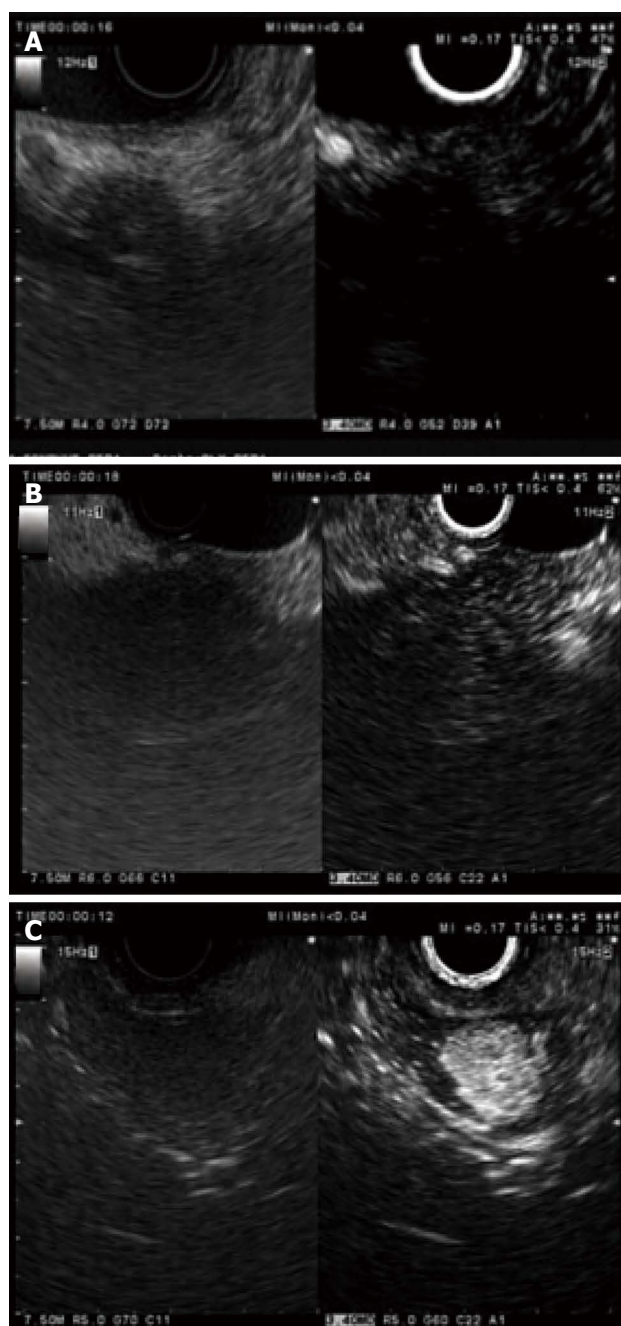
Typical contrast-enhanced harmonic endoscopic ultrasound images of pancreatic tumors. A: Pancreatic carcinoma with hypoenhancement. Conventional EUS (left) shows a hypoechoic mass at the pancreas tail. Contrast-enhanced harmonic endoscopic ultrasound (CH-EUS) (right) indicates that the mass has hypoenhancement compared with the surrounding tissue; B: Chronic pancreatitis with iso-enhancement. Conventional EUS (left) shows a hypoechoic mass at the pancreas body. CH-EUS (right) indicates homogeneous enhancement mass similar to the surrounding tissue; a margin is not observed; C: Neuroendocrine tumor with hyperenhancement. Conventional EUS (left) shows a hypoechoic mass at the pancreas body. CH-EUS (right) indicates that enhancement in the mass is higher than in the surrounding tissue (Kwek *et al.*^[65]).
